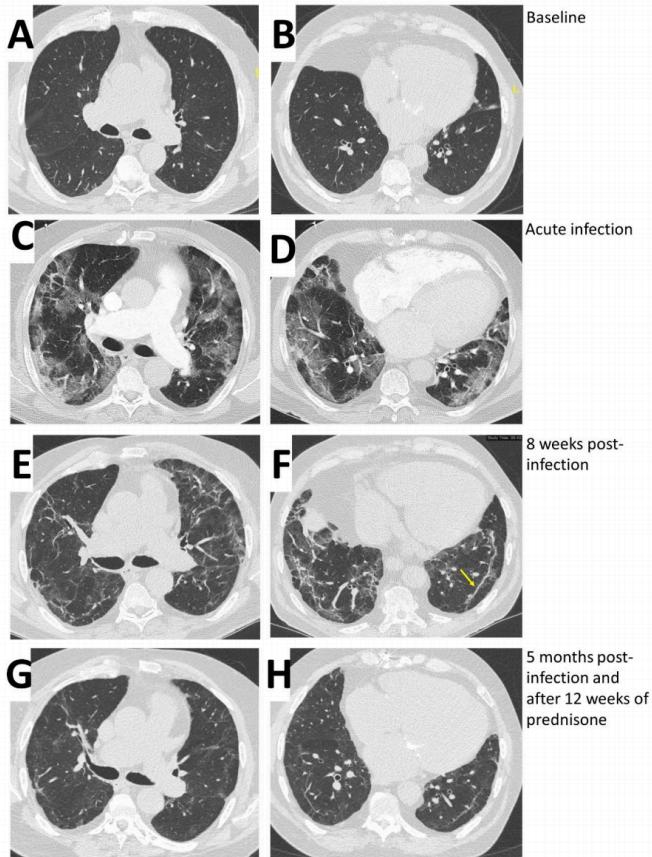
Computed tomography one year before COVID-19 infection showing normal lung parenchyma (A, B), at the time of COVID-19 infection showing extensive ground glass attenuation (C, D), eight weeks following COVID-19 infection showing persistent groundglass attenuation and linear opacities (arrow) (E,F) and 5 months following COVID-19 infection demonstrating improvement after prednisone therapy. A, C, E, G: axial views below the carina; B, D, F, H: axial views in the lung bases.
